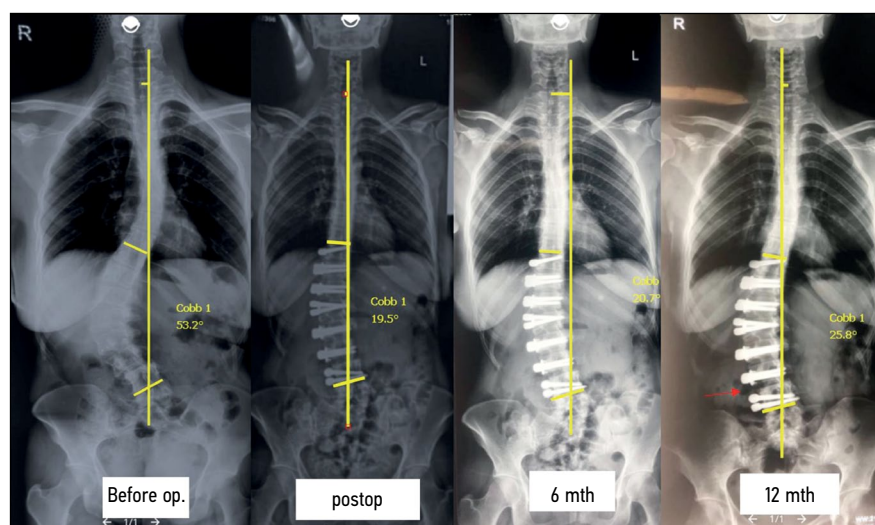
AP X-ray of a 32-year-old female patient after lumbar spine anterior dynamic scoliosis correction at the observation stages. There is an increase in the angle between the heads of the L3–L4 screws (level where the nucleotomy was not performed) 12 months after the surgery. There is no significant loss of correction, dynamic monitoring is recommended.
